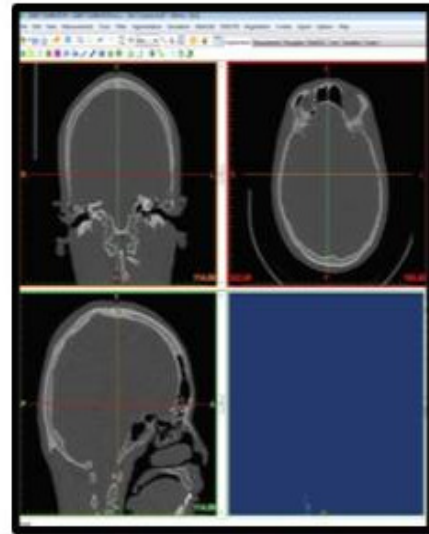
The CT imaging suite provided at Radiology Department, HUSM.
